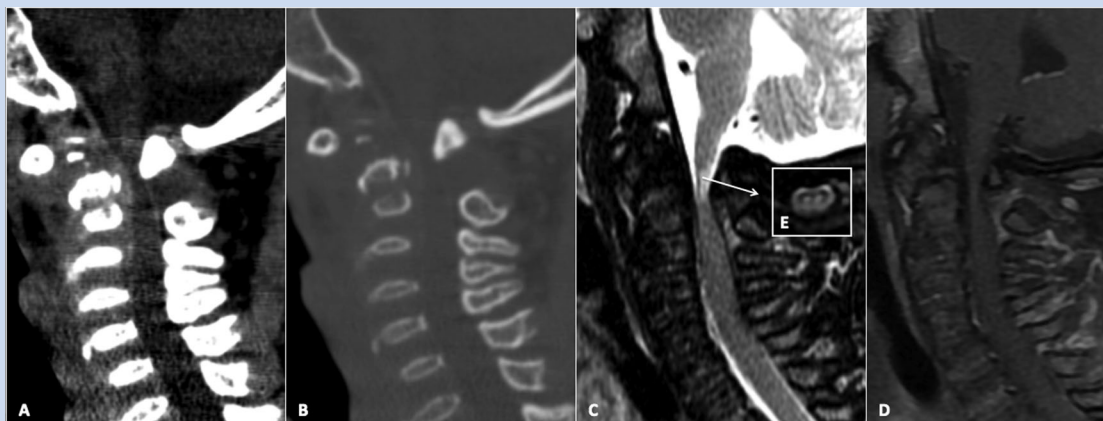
Patient 5: A—Non enhance sagittal CT soft tissue window, B—Sagittal CT bone window; C—Sagittal T2 WI MRI; D—Sagittal post gadolinium T1 WI; E—Axial T2 WI MRI at C2 level. Findings: C1–C2 spine stenosis; focal myelomalacia secondary to ischemic changes of the compressed cord (C,E); anterior displacement of C1 posterior arch/atlandoaxial subluxation, odontoid hypoplasia with soft tissue mass, *os odontoideum*, vertebral bodies flatness with anterior and posterior indentations.
